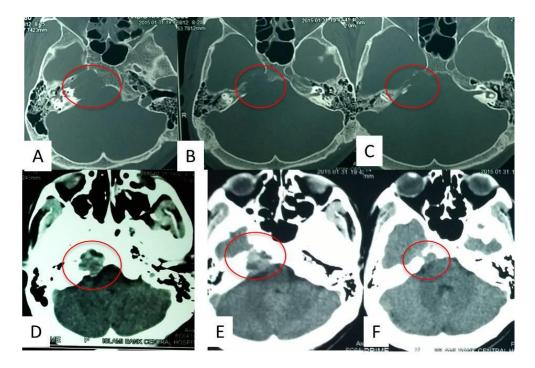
CT scan of head axial images. A,B&C(bony window) showing destructive, expansile bony lesion in right sided petrous apex. D, E &F- mixed density bone destructive lesion in right petrous apex
